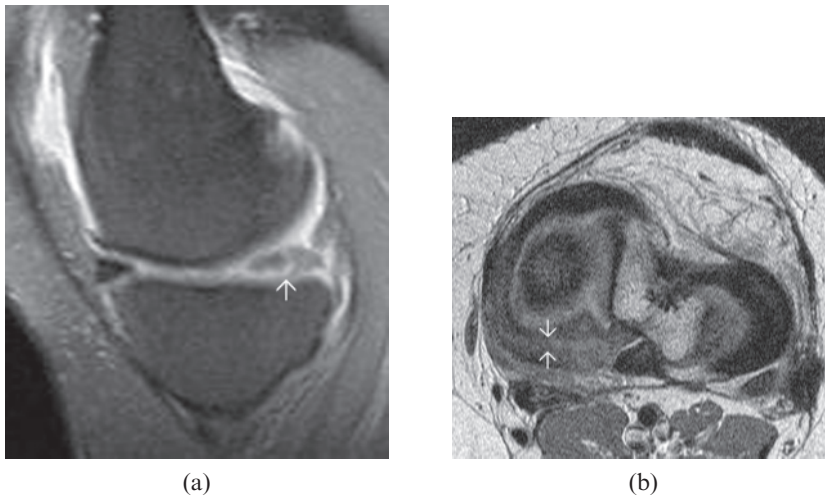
A 53-year-old male with right knee pain demonstrated horizontal and flap tears in the lateral meniscus on both arthroscopy and MRI. (a) The linear increased signal intensity in the corpus of the lateral meniscus on the sagittal fat-suppressed proton density-weighted (PDW) MR image was evaluated as a horizontal tear (cleavage tear, arrows) (4 points, definitely present). (b) The irregular increased signal in the corpus of the lateral meniscus on the axial PDW MR image was evaluated as a horizontal tear (arrow) (4 points, definitely present). (c) Axial PDW MR image showing flap tears over the posterior horn of the lateral meniscus (arrow) (4 points, definitely present). Arthroscopy revealed (d) horizontal and (e) flap tears and the patient was treated by partial meniscectomy.
